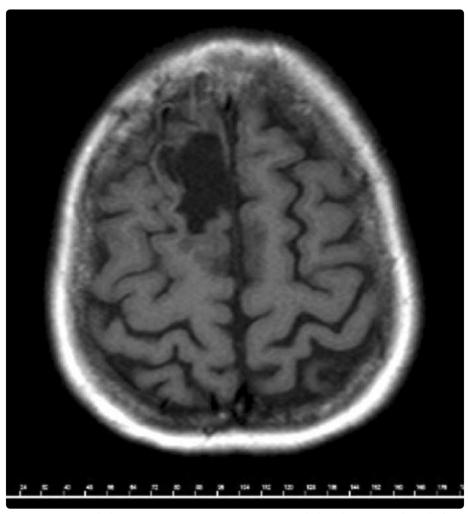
MRI revealed a 4 × 2 × 3 cm postoperative cystic encephalomalacic area in the right frontal lobe and superior and middle frontal gyrus.
